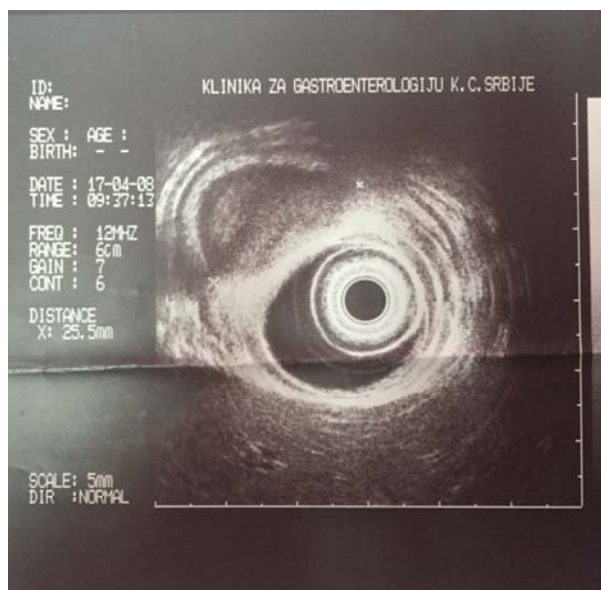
Endoscopic ultrasonography shows hypoechoenic, homogenous lesion belonging to the fourth gastric wall layer near gastroesophageal junction.
